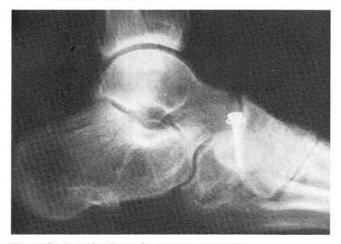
Lateral radiograph, 1 year postoperative.
